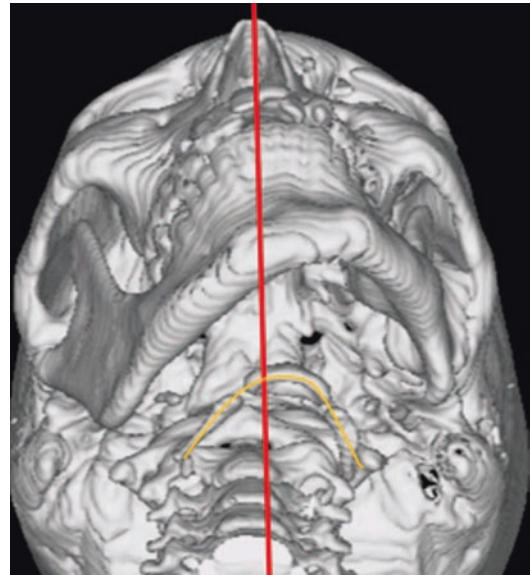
A three-dimensional (3D) reconstructed computed tomography image of left temporomandibular joint ankylosis revealing a rotated hyoid complex to the left side (*Red line*: Mid sagittal plane; *Yellow curve*: rotated hyoid towards the side of ankylosis) (Reprinted with permission from Springer Nature Customer Service Centre GmbH, Computed tomography analysis of hyoid apparatus in temporomandibular joint ankylosis. *J. Stomat. Occ. Med.* (2012) 5:99–103. <https://doi.org/10.1007/s12548-012-0046-7>)
